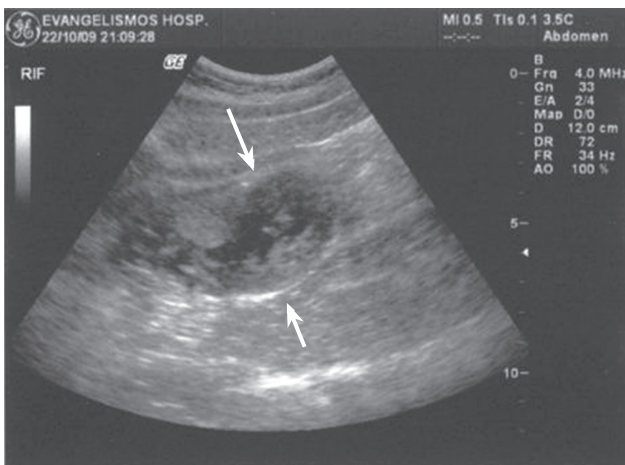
Abdominal ultrasound showed a mass of mixed echogenicity in the right iliac fossa (arrows).
